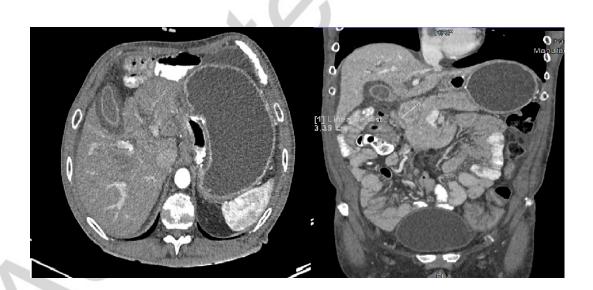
CT scan showing gastric obstruction of the biliopancreatic loop with intraluminal parietal tumor of 3.39 cm in the antrum.
